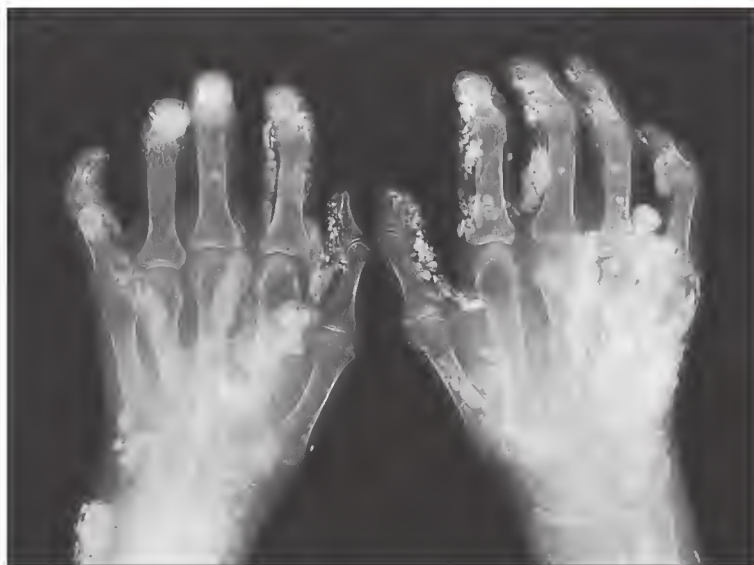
Anteroposterior radiograph of the hands of a patient with severe subcutaneous calcification associated with mild scleroderma.
